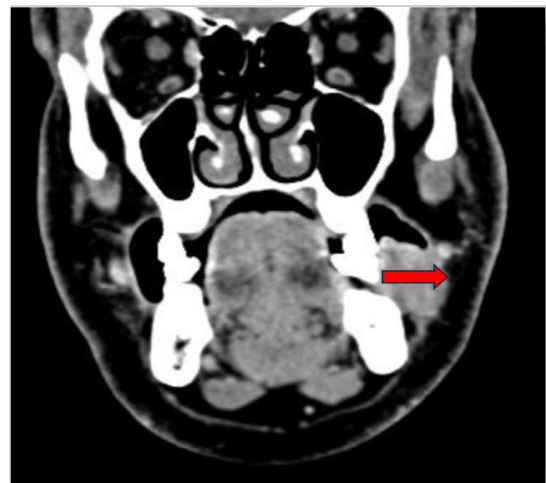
Measurement of depth of invasion of tumour using computed tomography (Coronal 1 mm section) scan.
